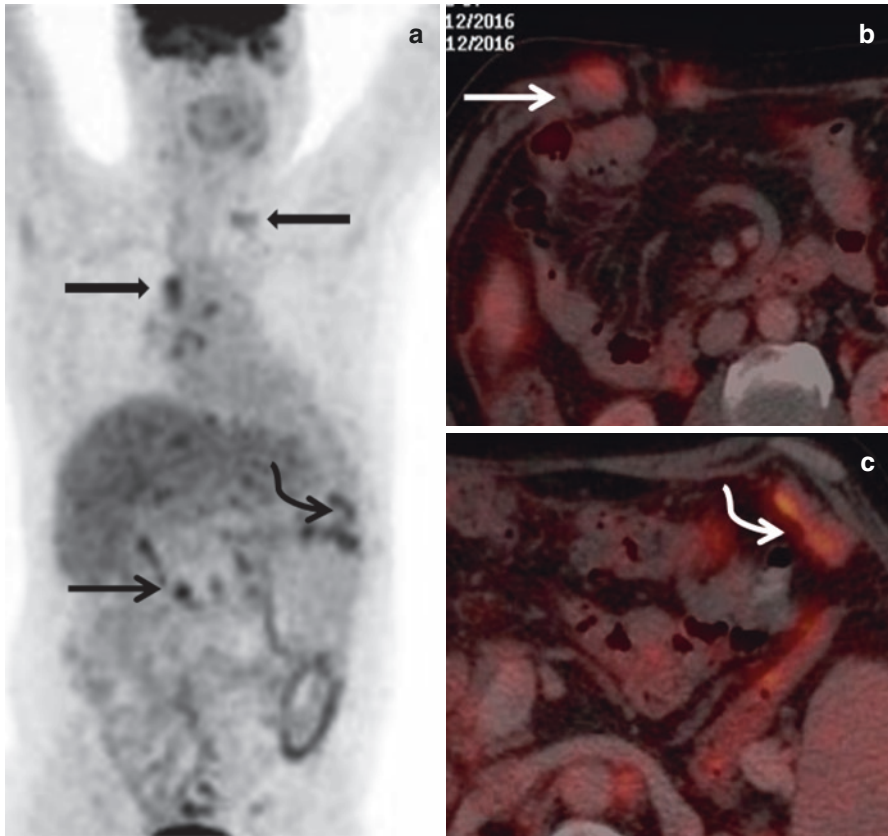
55-year-old male, a case of GB carcinoma post-cholecystectomy. ^{18}F -FDG PET/CT shows hypermetabolic metastatic supraclavicular, mediastinal nodes (*block arrows* in a), anterior abdominal wall deposits (*arrow* in a, b), and peritoneal deposits (*curved arrow* in a, c)
